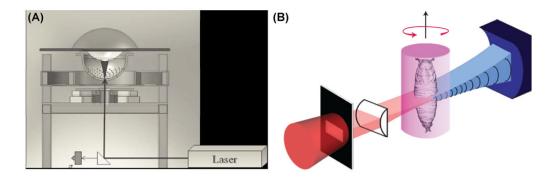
Inverse-reconstruction based photoacoustic computed tomography (PACT)
